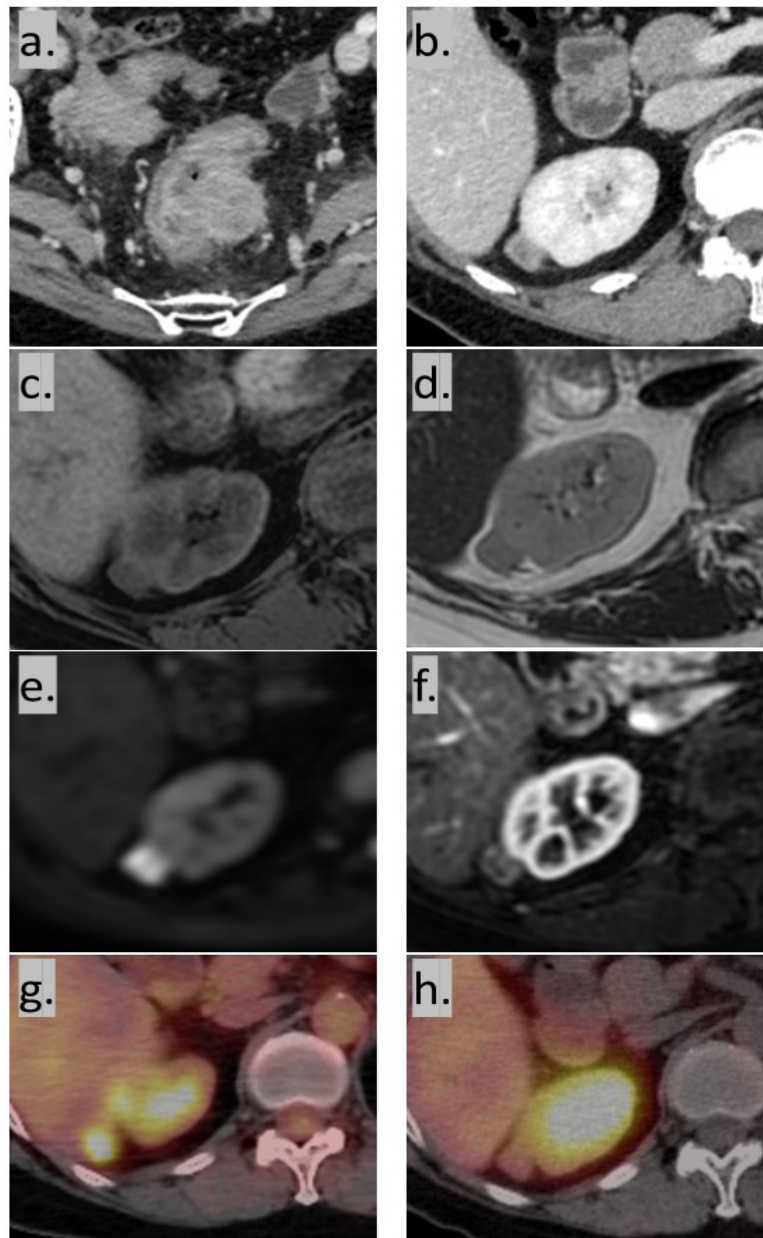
Preoperative imaging findings. Abdominal contrast-enhanced CT (a, b) showed a 30-mm tumor on the anterior-left wall of the rectum with a sign of infiltration beyond the wall (a), along with an enhanced mass lesion of 15 mm in size at the upper pole of the right kidney (b). On renal MR images (c-f), the renal tumor was depicted as an isointense and hyperintense mass in comparison to renal parenchyma on T1- (c) and T2- (d) weighted images, respectively. Furthermore, the mass lesion showed a hyperintense signal on diffusion-weighted images (e) and a clear enhancement with contrast material (f). FDG-PET (g) and octreotide scintigraphy (h) showed significant (SUVmax 11.0) and mild uptake in the mass lesion at the upper pole of the right kidney, respectively.
